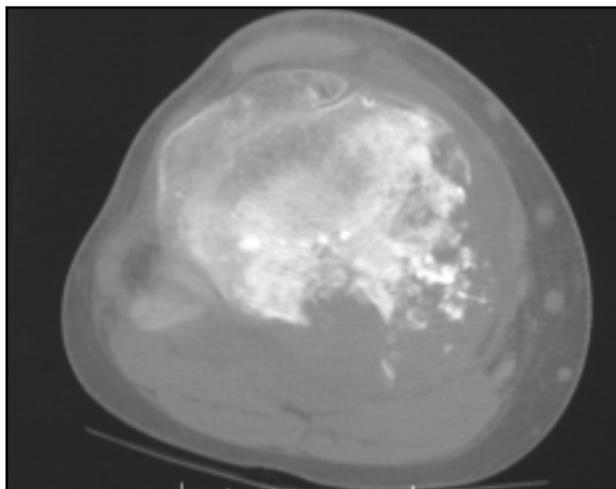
Axial CT scan reveals an osteolytic and osteoblastic process with soft-tissue extension beyond the disrupted posteromedial cortex.
